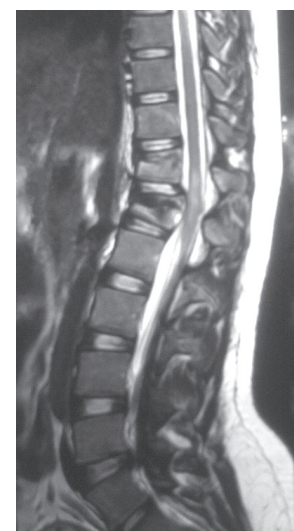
Sagittal T2 weighted MRI image showing anterior wedging of D11 and D12 vertebrae, with heterogeneous signal intensity. Wedging is more pronounced in D12 vertebrae with convex posterior bulge causing severe anterior thecal sac narrowing and cord indentation, terminal spinal cord at this level is showing T2 hyperintensities suggestive of cord edema.
